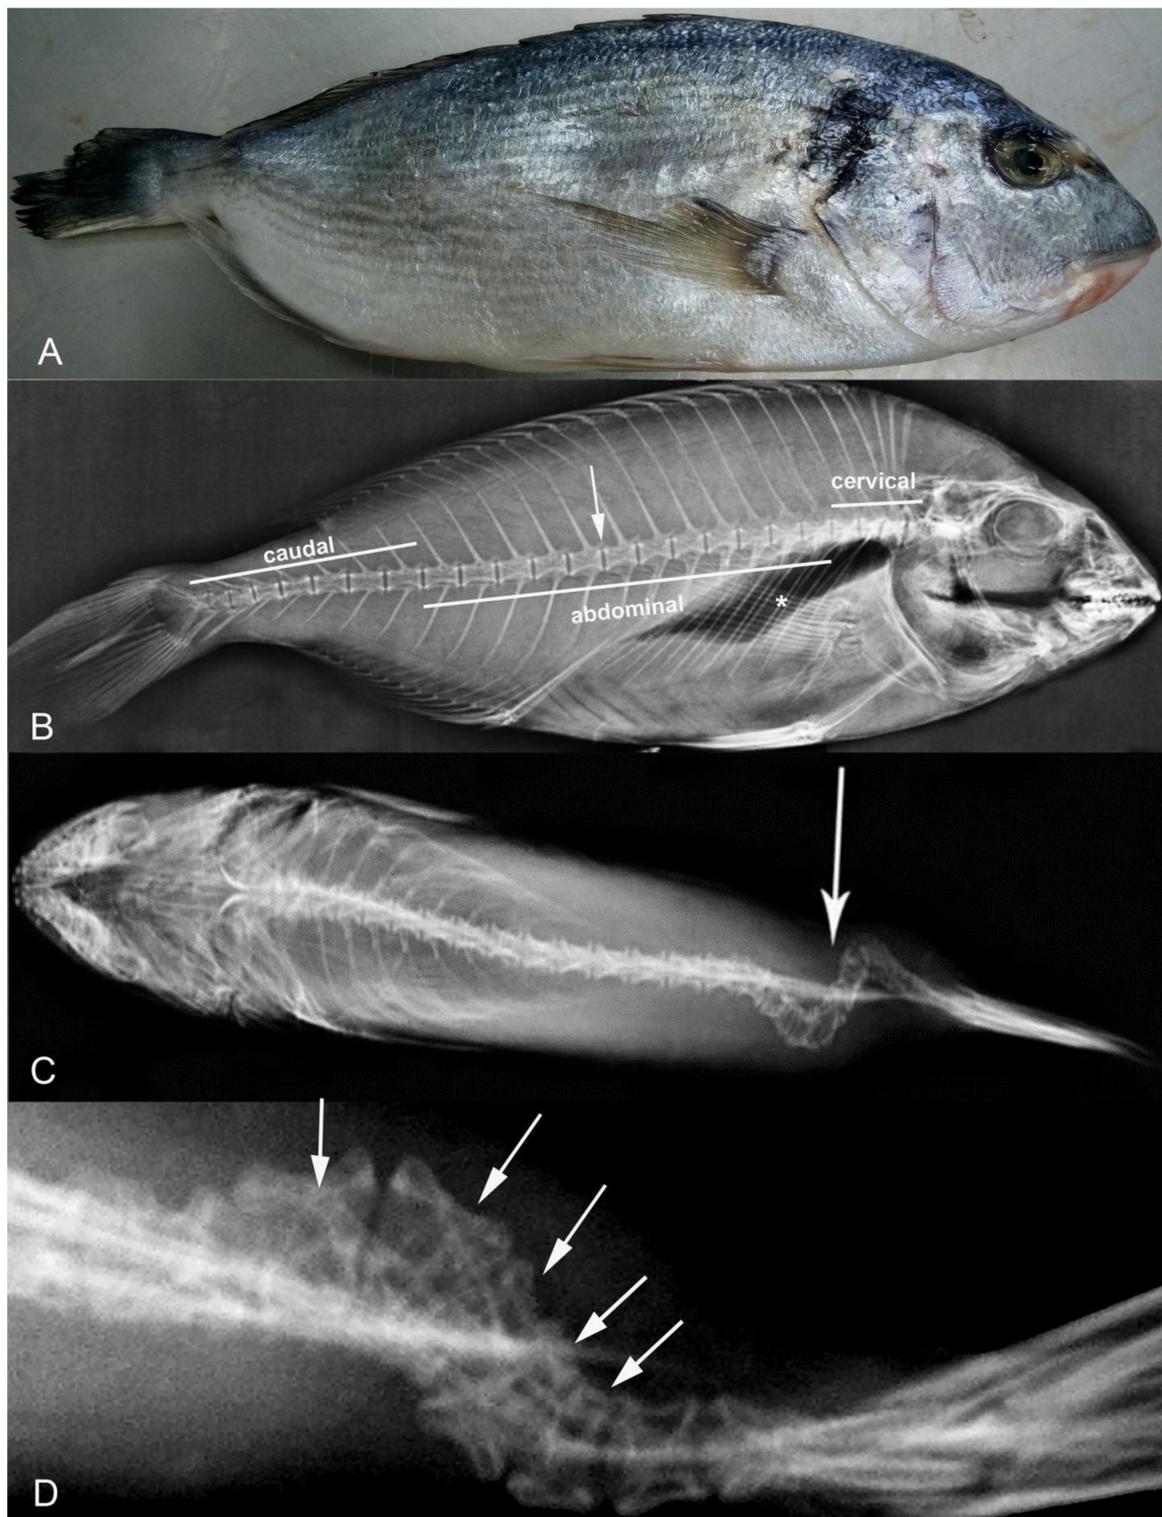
(A) Seabream with scoliosis at the caudal region. (B) X-ray of seabream without scoliosis. The cervical, abdominal, and caudal regions are shown. Inter-vertebrae space is highlighted with an arrow, whereas swim bladder is indicated with a star. (C) Apical X-ray of seabream with scoliosis. The scoliosis area is highlighted with an arrow. (D) Magnified apical X-ray of seabream caudal region with scoliosis. Deformed vertebrae with trapezoid shape are highlighted with arrows.
